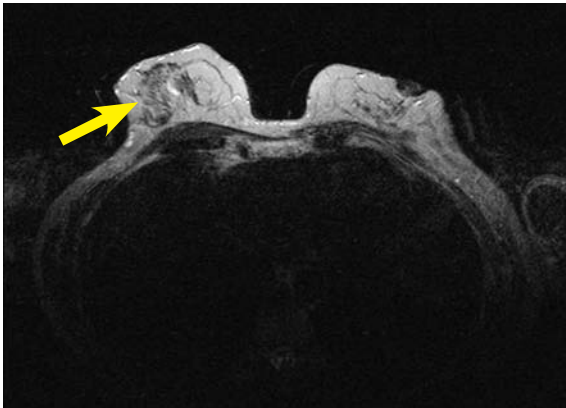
Axial T2-weighted image, a hyperintense signal in the right breast (arrowhead).
